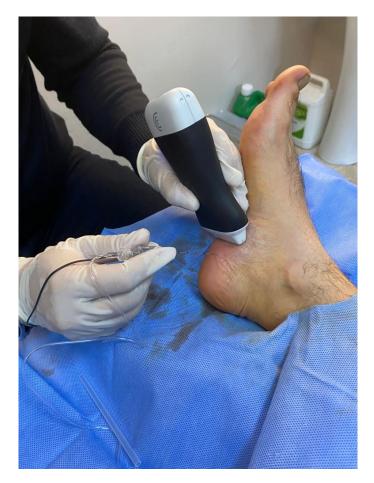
PRP (platelet-rich plasma) application under ultrasound guidance in the treatment of plantar fasciitis.
